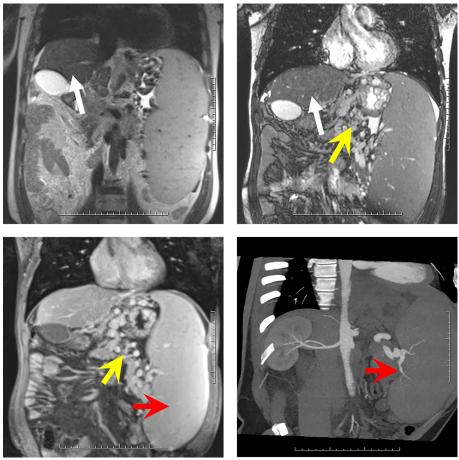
Abdominal enhanced magnetic resonance imaging
